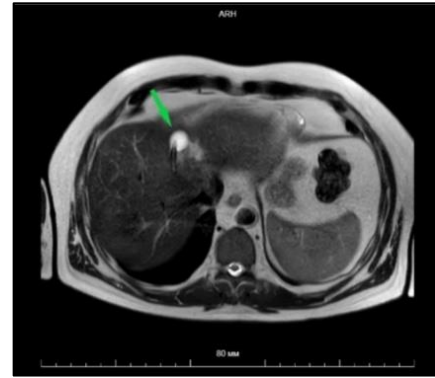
Abdominal MRI (final control). The image shows the drainage tube (green arrow), the abscess cavity is completely absent.
